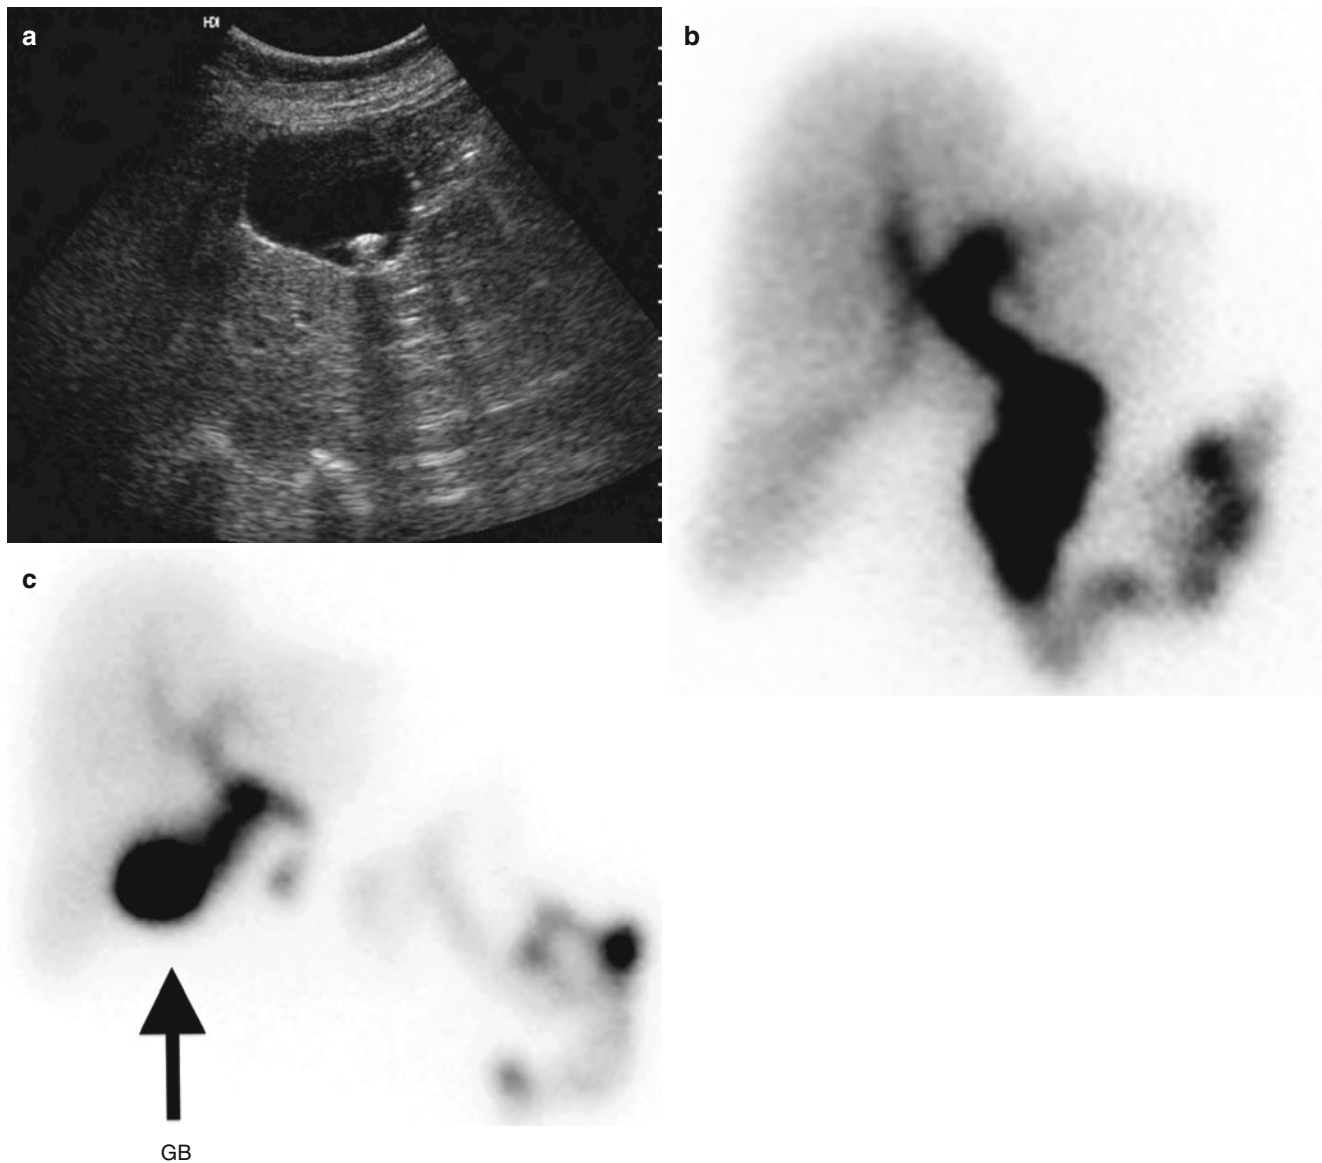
Chronic calculous cholecystitis. Gallstones by ultrasound (a). On HBS, gallbladder nonvisualization at 1 h (b) after ^{99m}Tc IDA analog IV, but visualization (GB) at 20 min following morphine sulfate IV (c)
